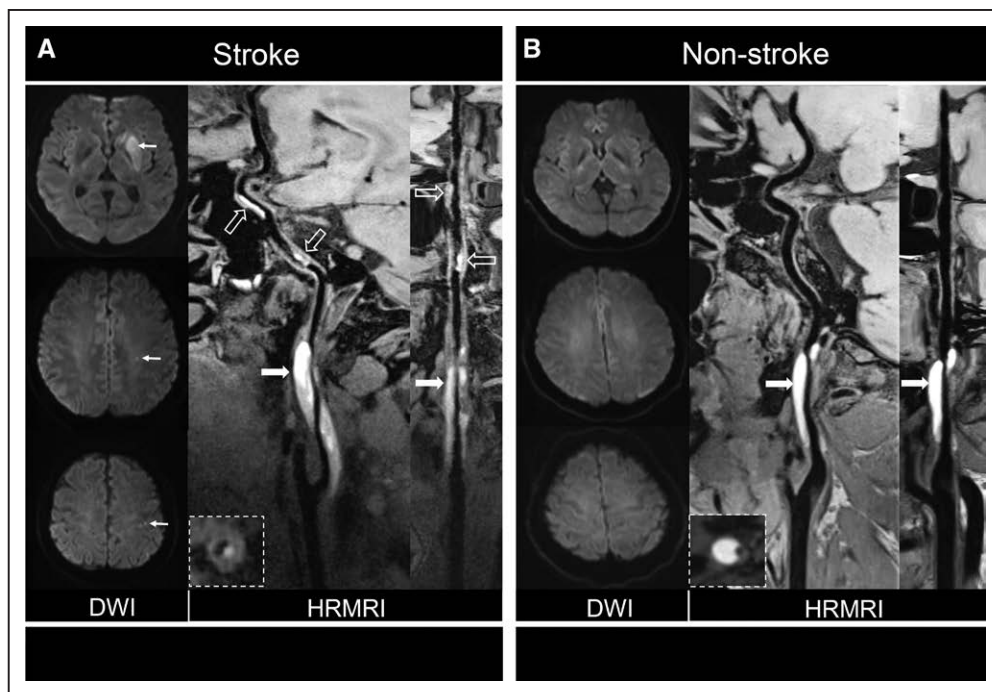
Comparison of patients with cervicocranial artery dissection with or without ischemic stroke. A, Diffusion-weighted imaging (DWI) showed acute ischemic stroke in left basal ganglia and centrum ovale (arrows) of 48 y of male patient. Curved planar reformation of high-resolution magnetic resonance imaging (HRMRI) demonstrated intramural hematoma (arrows) inner the vessel wall of C1 segment of left internal carotid artery (ICA) and distal intraluminal thrombus (dashed arrows) on the vessel wall of C2 and C4 segments of the ICA. Stretched curved planar reformation of HRMRI image depicted irregular surface and intraluminal thrombus. B, DWI showed no ischemic stroke in a 37-y-old female patient. Curved planar reformation of HRMRI image depicted a smooth vessel wall surface (arrows) without intraluminal thrombus. Stretched curved planar reformation of right ICA demonstrated the intramural hematoma and normal distal vessel wall.
